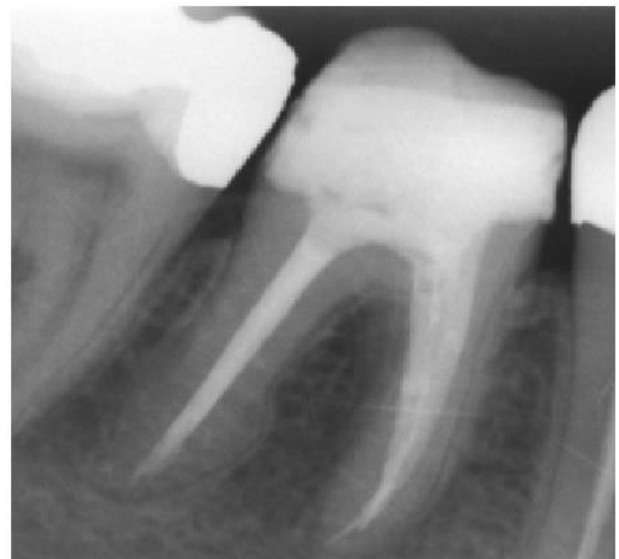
Follow-up radiograph taken 1 year after the completion of root canal treatment.
